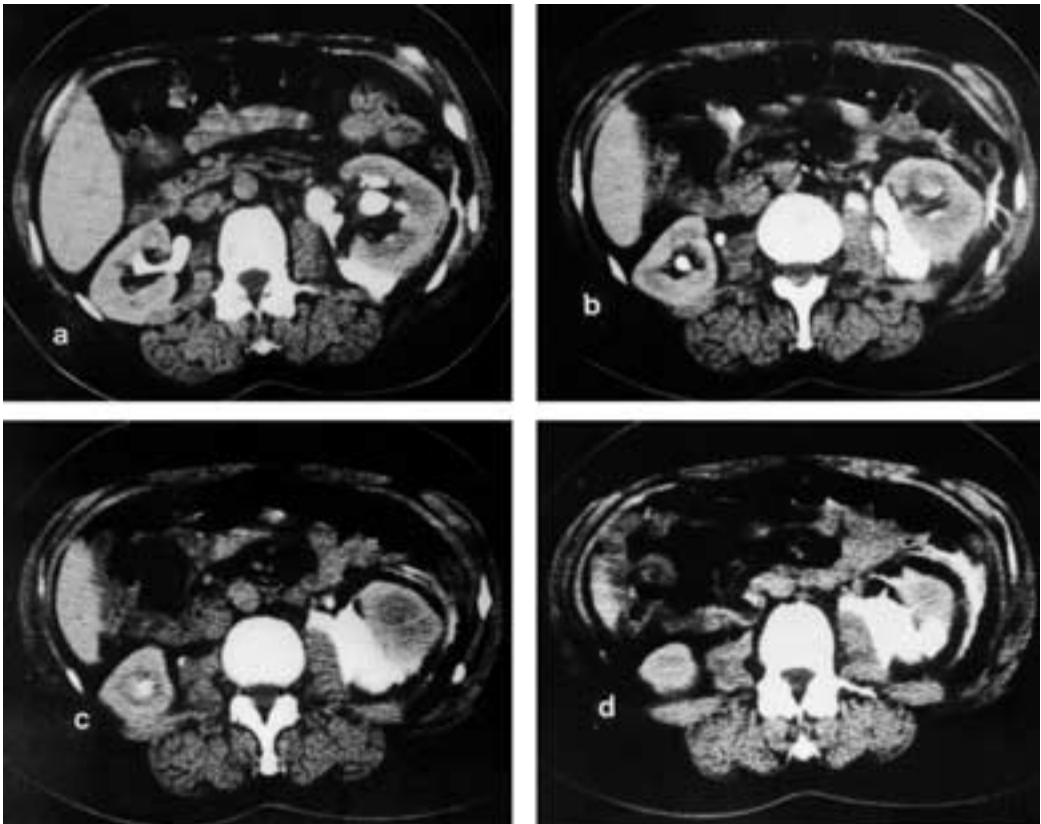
CT finding: (a) dilatation of the canal system of the left kidney, with the contrast leaking into the medial and dorsal perirenal space, without any sign of the trauma of the kidney or perirenal haematoma; (b) and (c) the contrast found in the medial part of the kidney and pylon; d) the contrast in the ureter dispersed distally along the psoas muscle and also in the periuretral space.
